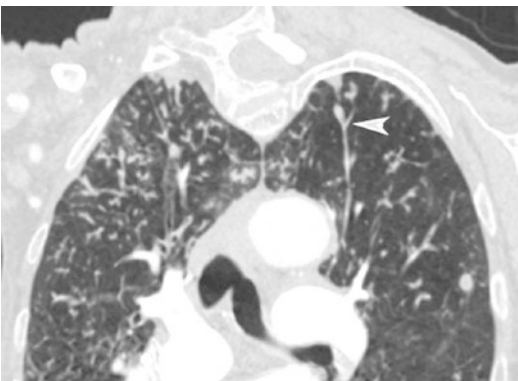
CT coronal image of the chest demonstrates the feeding vessel sign (*arrow*)
